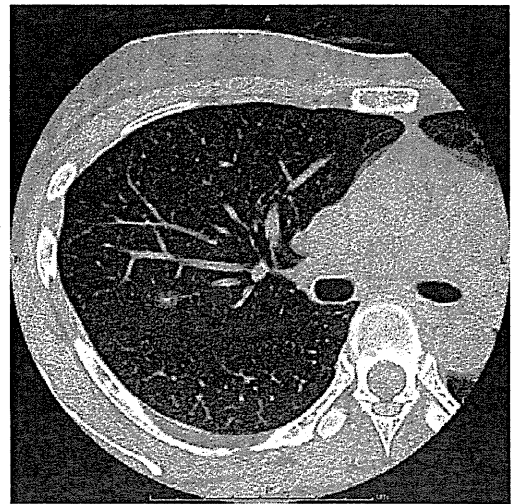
Chest computed tomography image before surgery. The tumor shows ground-glass attenuation with a solid area in the center.
